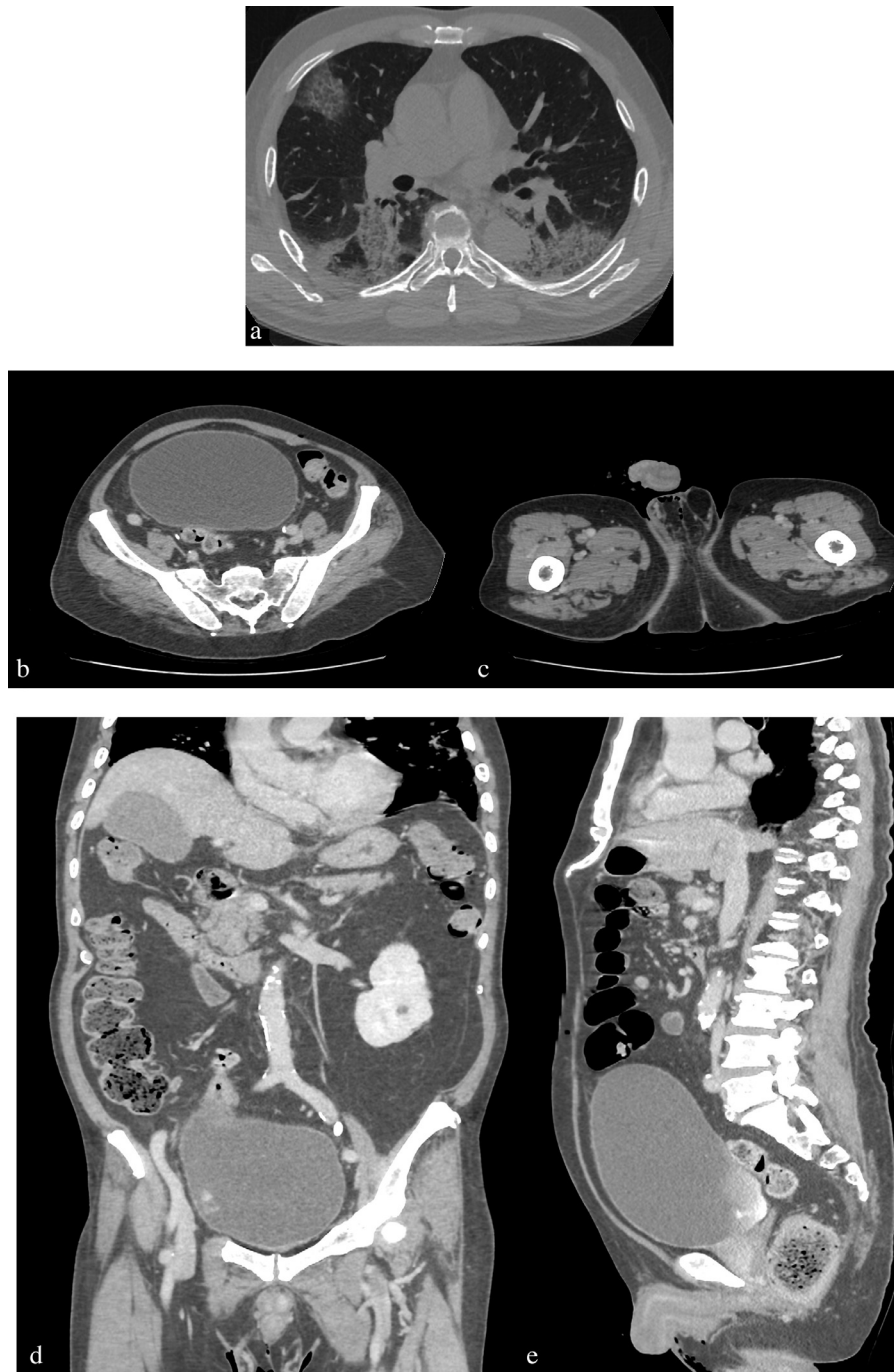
Thoraco-abdominal CT Scan on day 26. 5A-E Bilateral viral Pneumonia was still seen with improvement. No more emphysema subcutis at the thoracic wall nor abdominal wall were detected. Only minimal emphysema subcutis were still seen at both scrotal regions.
